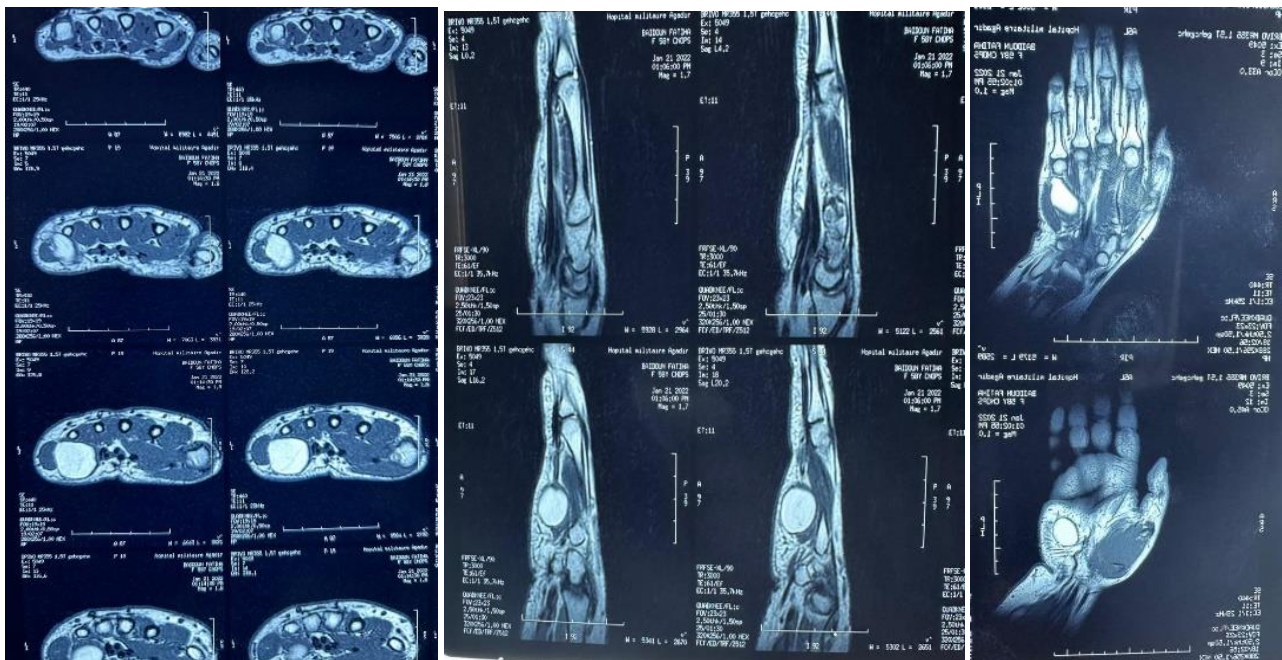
Appearance of the mass on MRI
